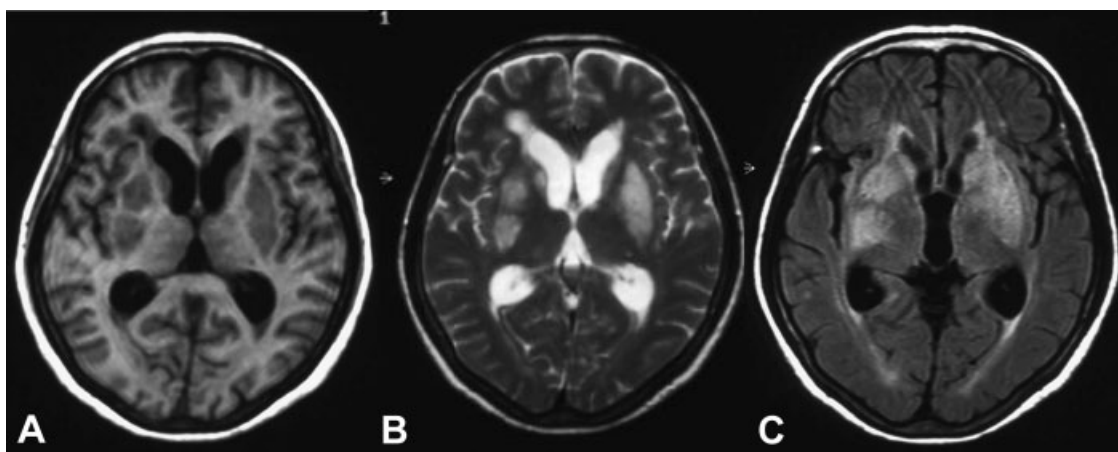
Brain MRI with T1-weighted images revealing slightly low-signal intensity lesions in the bilateral basal ganglia (A). T2-weighted and FLAIR images show diffuse high-signal intensity lesions in the bilateral basal ganglia (B, C).
